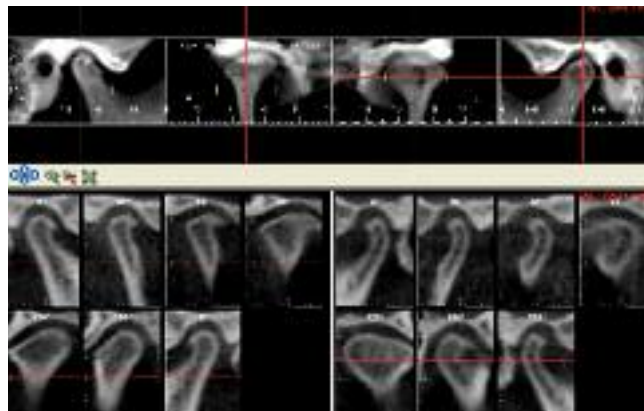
CT of mandibular condyles (right and left).
